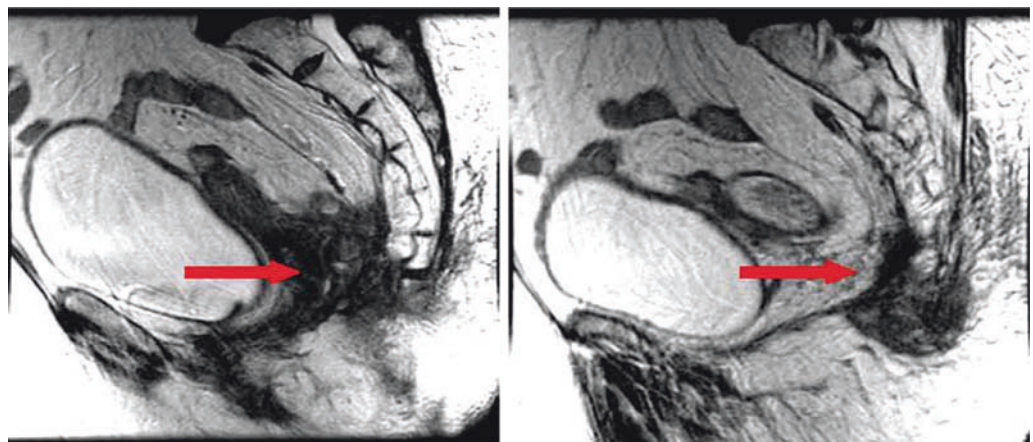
MRI showing central and sacral recurrence.
